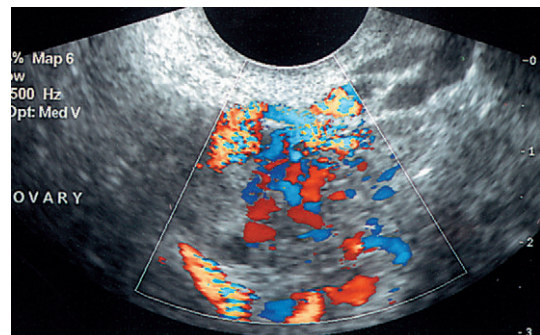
Colour flow Doppler showing adnexal hyperaemia in pelvic inflammatory disease.
